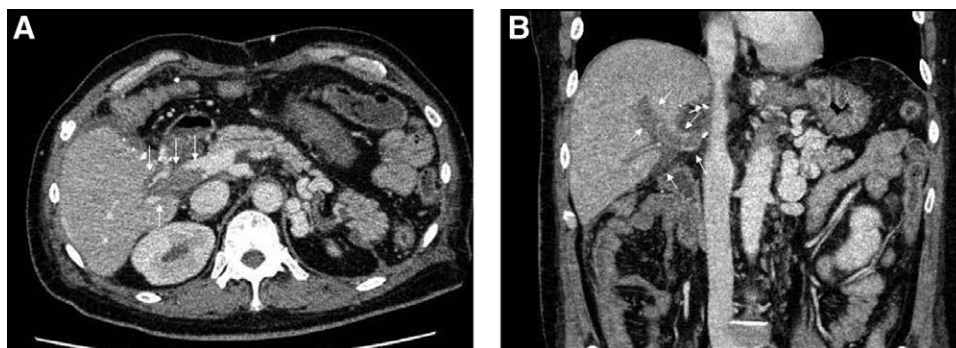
Computed tomography image showed portal vein thrombosis. A and B, Diffuse portal vein thrombus was present from the extrahepatic to the intrahepatic portal vein (arrow).
